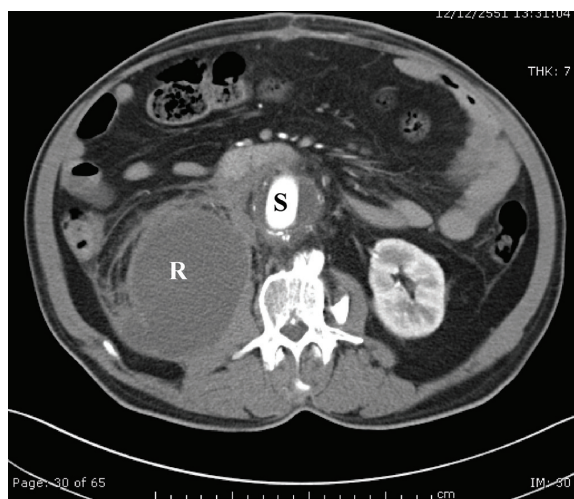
Pre-operative axial CT-angiography reveals retroperitoneal hematoma (R), aneurysmal sac (S) and a leaking point (arrow). Pre-operative reconstructed CT-angiography shows ruptured AAA with a leaking point (arrowhead).
